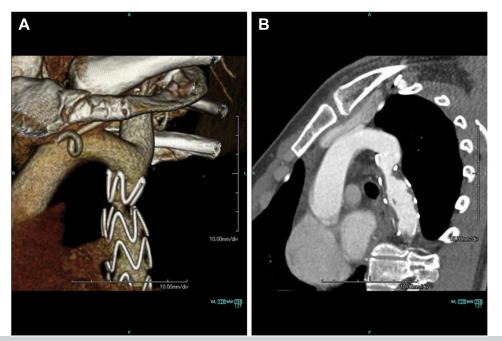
Computed tomography (CT) scan at 1 year of follow-up showing infolding of the stent graft (A) and thrombus formation inside the graft (B).
